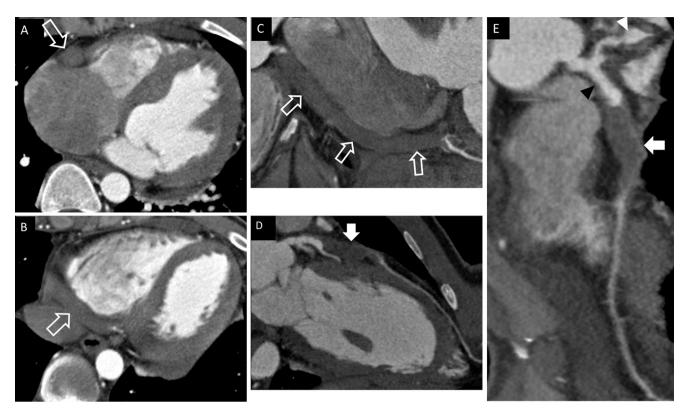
22 year old Chinese man with fever, pharyngitis, arthralgia, and enlarged palpable cervical lymph nodes. A diagnosis of polyarteritis nodosa was made based on the clinical and radiological findings. (A, B, C) The right coronary artery shows extensive encasement with thrombosis (open arrows). He subsequently developed an inferior septal infarct. (D, E) Curved multiplanar reformations from CT coronary angiogram demonstrates ectasia of the left anterior descending, ramus intermedius, proximal left circumflex arteries. Soft tissue encasement and thrombosis of the proximal and mid left anterior descending artery is seen (solid arrows).
